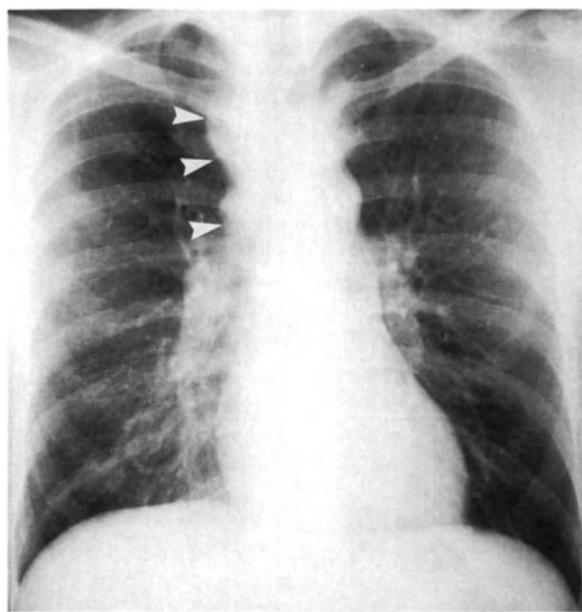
Lymphadenopathy. Hodgkin's disease. A Chest radiograph shows asymmetric right paratracheal and right anterior mediastinal lymph node enlargement (arrowheads). B Following radiotherapy and chemotherapy, the lymph node masses have resolved, but calcification is visible in nodes (arrows) overlying the right hilum.
